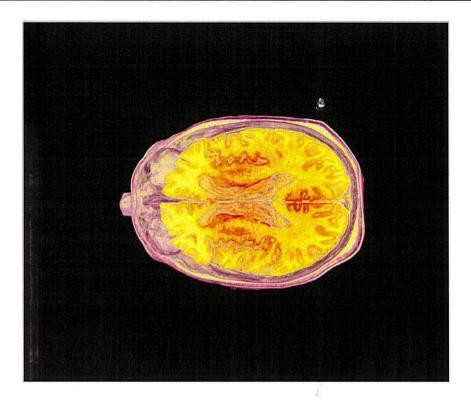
A volume rendering of an MRI scan of the human head with a transfer function applied to produce pseudo colour.
